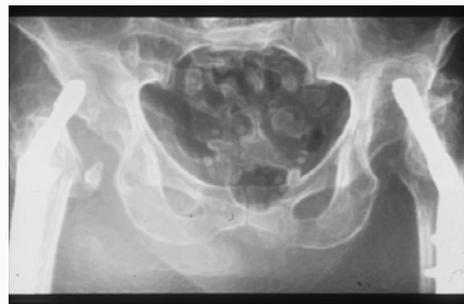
Nineteen months later she was again admitted through the emergency department to the intensive care unit for hypovolemic shock. She was hypothermic (32°C), with severe anemia (hb at 2.7) and metabolic acidosis (ph 6.9). Clinically, large bruises and hematomas were observed on both thighs. The femoral pulses were absent. Pelvic X-ray showed a total lysis of the left and right femoral heads and necks.
